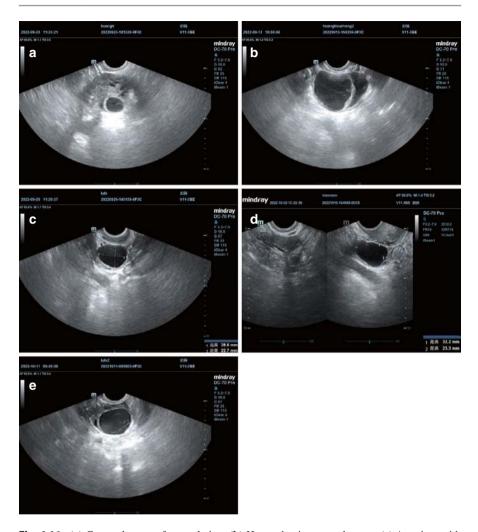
(a) Corpus luteum after ovulation. (b) Hemorrhagic corpus luteum. (c) A patient with DOR and a 30-day menstrual cycle. The follicle diameter was monitored on day 15 of the menstrual cycle, measuring 18 mm. The patient was instructed to have intercourse on that day. Upon recheck on day 19 of the menstrual cycle, it was found that the follicle had not ovulated and had enlarged to $28 \text{ mm} \times 23 \text{ mm}$. (d) For the same patient upon recheck on day 22 of the menstrual cycle, it was found that the follicle had not ovulated and had enlarged to $32 \text{ mm} \times 23 \text{ mm}$. (e) For the same patient a repeat ultrasound on day 29 of the menstrual cycle revealed further increase in follicular diameter with decreased translucency and a few flocculent echoes, suggesting a suspected diagnosis of LUFS
